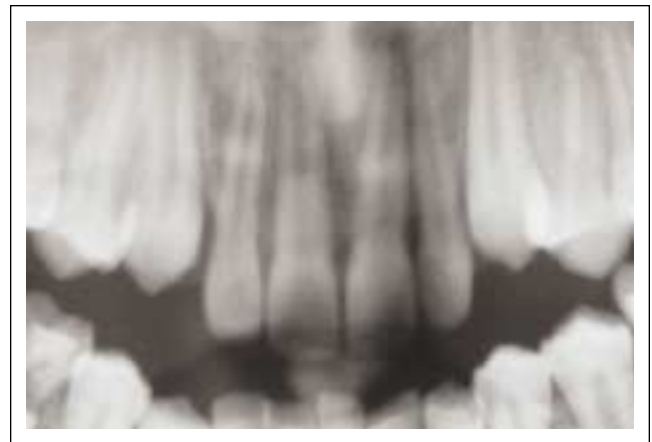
Six-month panoramic radiograph after treatment. Note no signs of root resorption and no periapical radiolucency.
